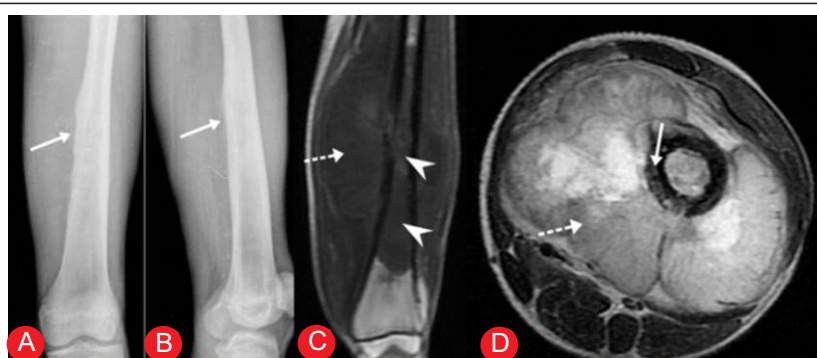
High-grade chondroblastic surface osteosarcoma AP (A) and lateral (B) radiographs shows cortical destruction with lifting of periosteum (arrow) and large soft tissue mass (C) Coronal T1-weighted MR image shows that the tumor involves the medullary cavity (arrowhead) and (D) Axial T2 weighted images shows high T2 signal areas with destruction of cortex (arrow) circumferential involvement by the soft tissue (dotted arrow).
